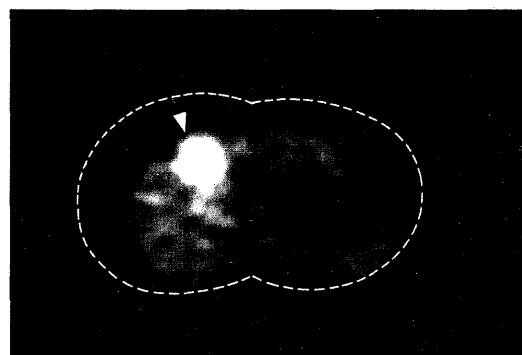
$^{18}\text{FDG}$  による肝細胞癌のポジトロン CT 像(50分後)。腫瘍部 (矢印) に  $^{18}\text{FDG}$  の高い集積がみられる。
